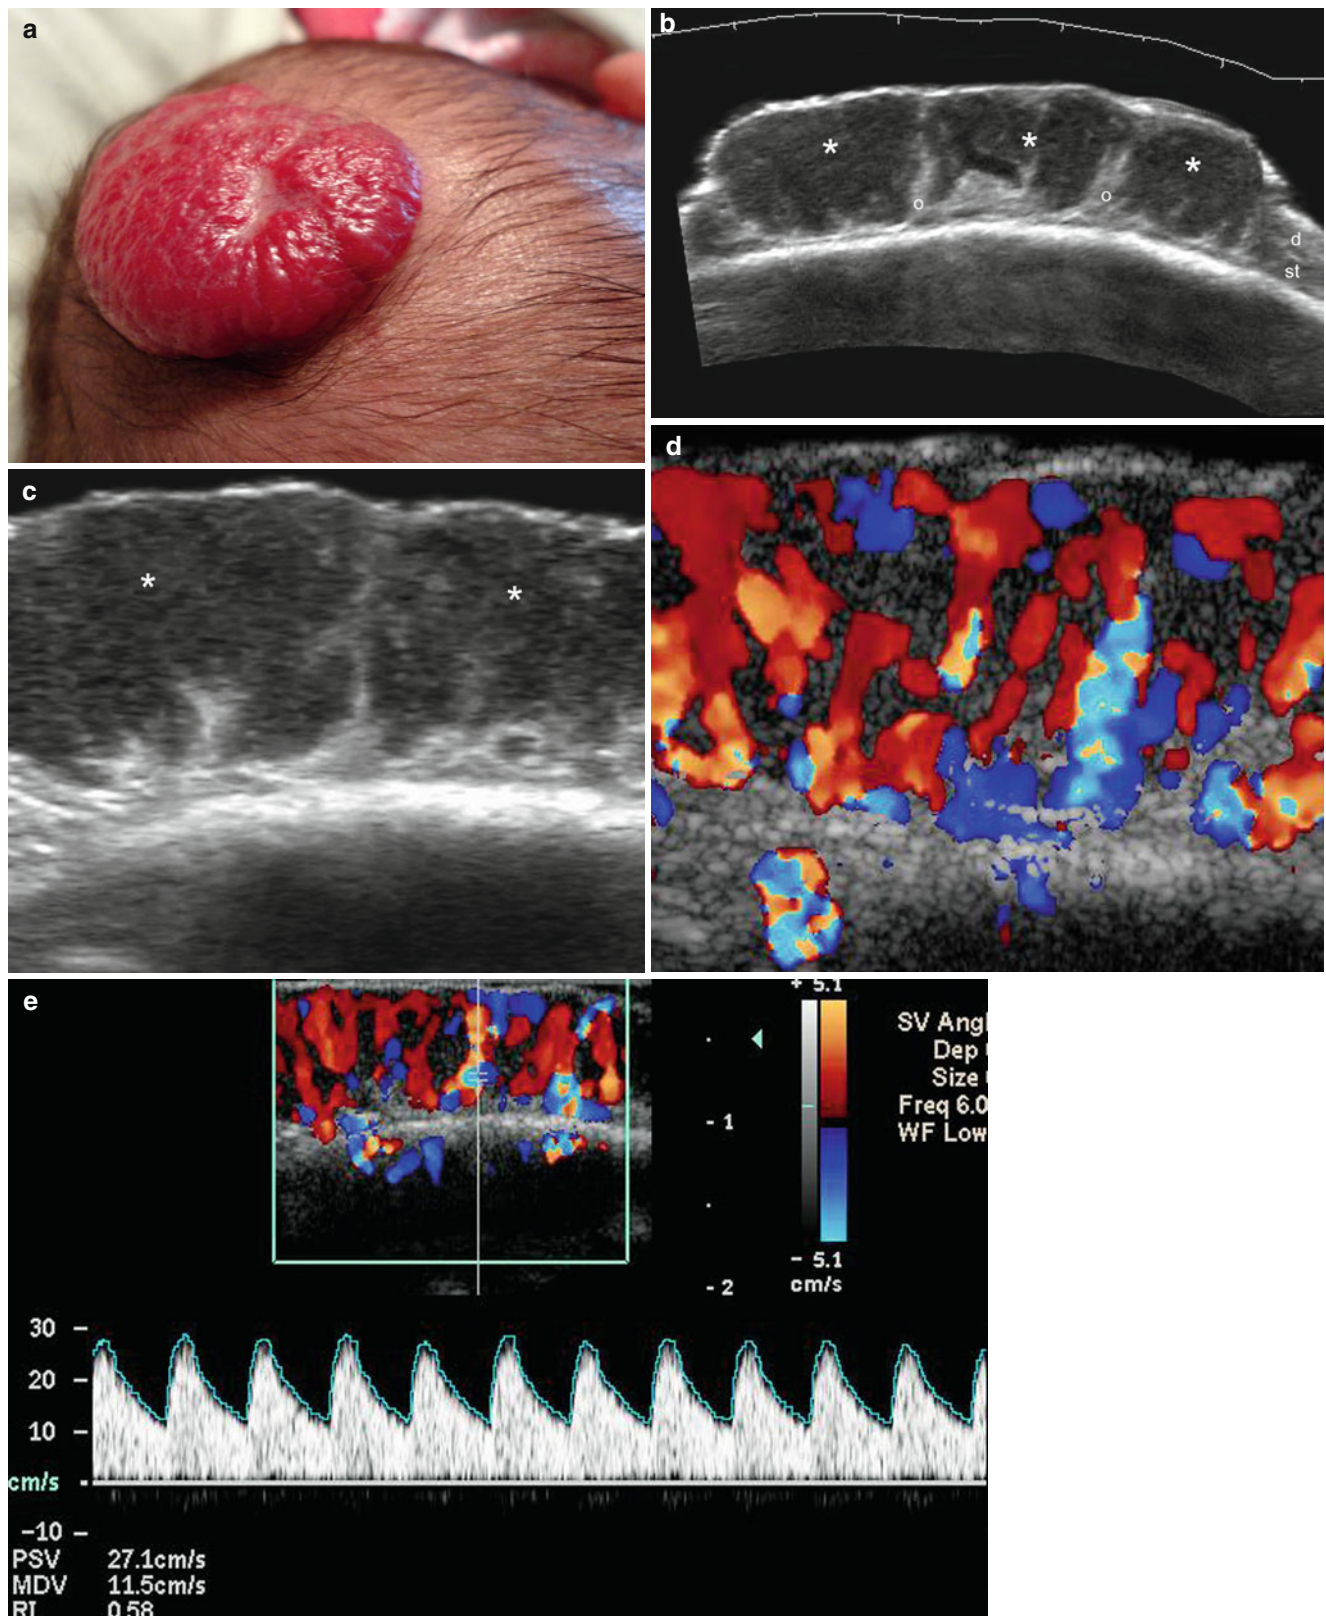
(a–c) Hemangioma. (a) Clinical image shows a reddish swelling in the scalp. (b) Grey scale ultrasound image (transverse view) demonstrates an ill-defined heterogeneous structure that presents an upper hyperechoic area (\*, mostly proliferative zone) and a lower
